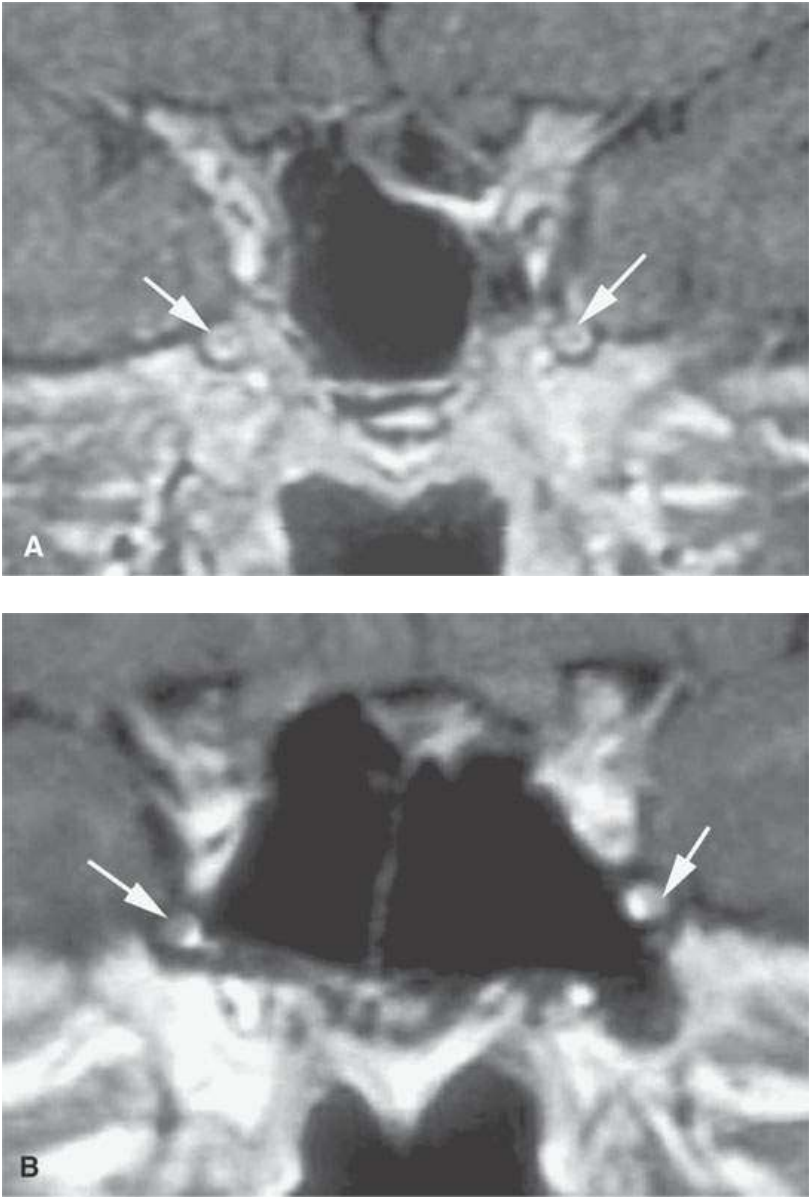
Contrast-enhanced magnetic resonance showing variations in normal perineural plexus enhancement around V2 within the foramen rotundum (arrows in the T1-weighted contrast-enhanced images in A and B).
